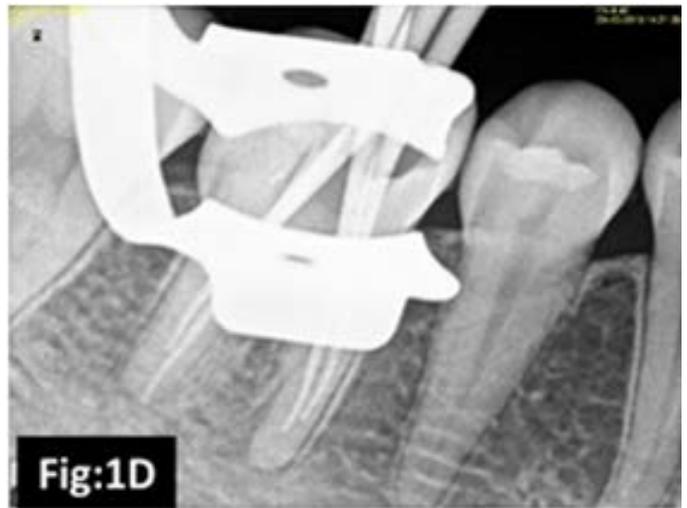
Master-cone radiograph
